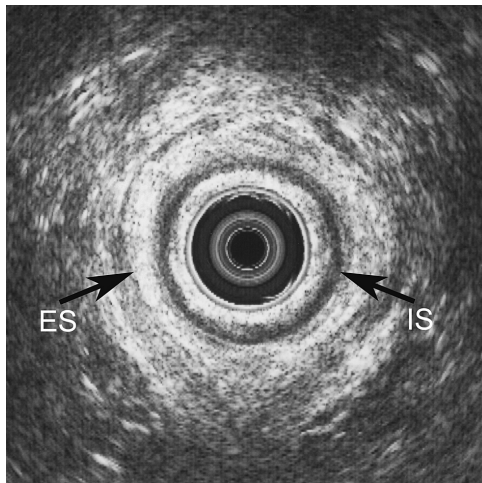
Transverse endoanal ultrasonography obtained from a 65-years-old man demonstrating normal anatomy at the mid-anal canal of the internal anal sphincter (IS) and external anal sphincter (ES). The top of the figure is anterior.
